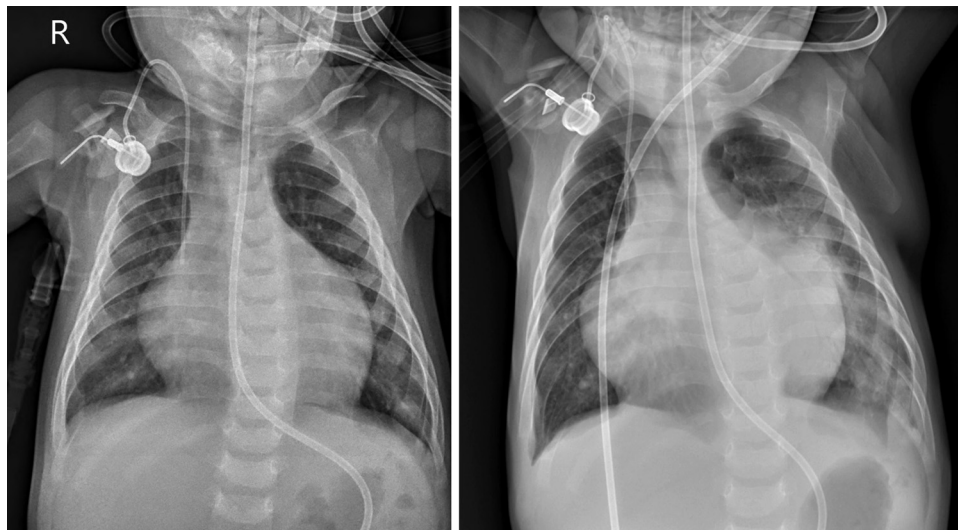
A: Chest film taken on hospital admission showing an abnormal (wide) cardiothoracic ratio, without visible lung abnormalities. R, right. B: follow-up radiograph obtained at day 3 after admission showing bilateral perihilar consolidation with air bronchograms, extending to left lung base, even in retrocardiac space.
